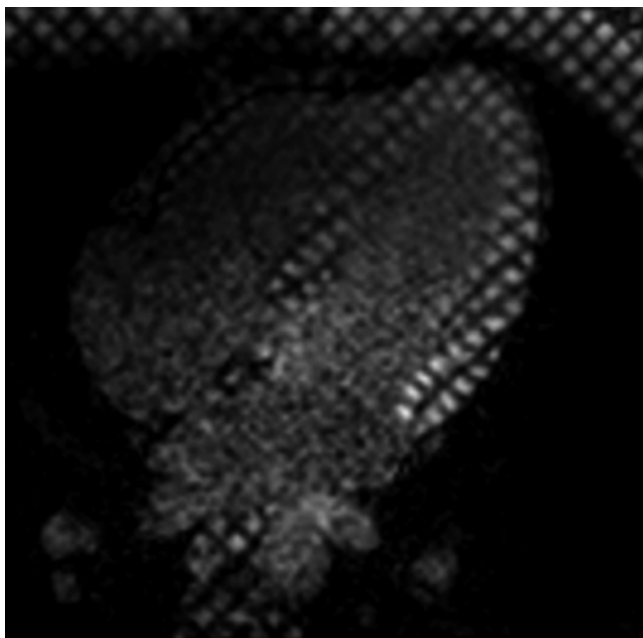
Four chamber view with MRI Tagging sequence.
